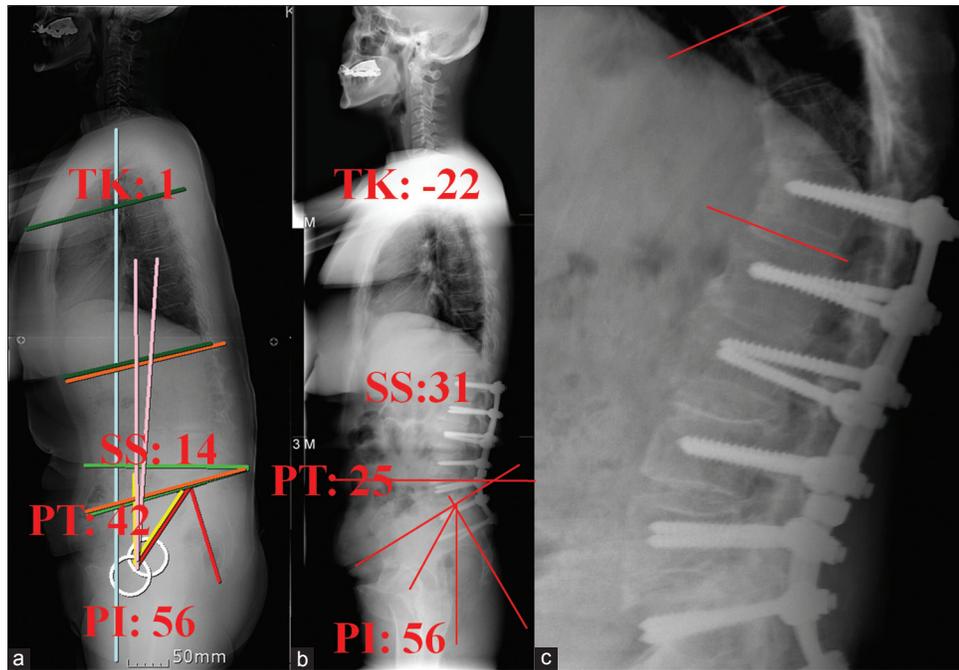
(a, b) Lateral standing radiograph of a 70-year-old woman who had undergone an L2 to sacrum posterior instrumented fusion. Patient presented with severe sagittal imbalance issues and osteoporosis. (c) Final lateral standing radiograph. At 3 years postoperatively, proximal junctional failure was developed
